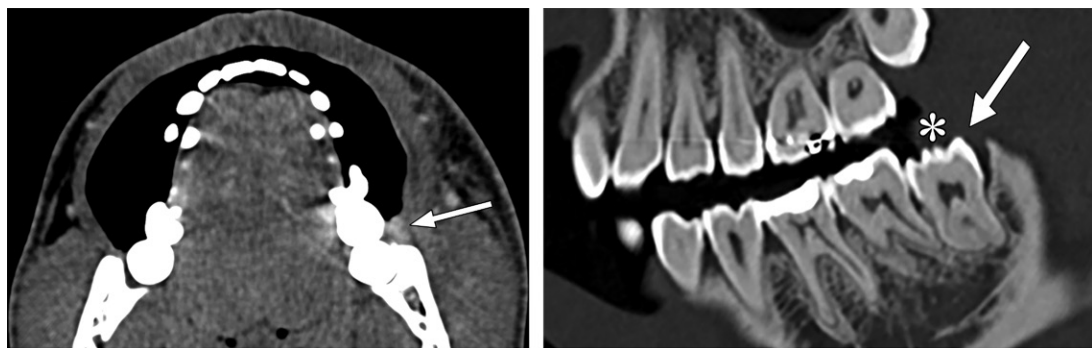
Pericoronitis. (a) Axial contrast-enhanced CT image (soft-tissue window) demonstrates enhancement of the pericoronal tissues (arrow). (b) Sagittal CT image (bone window) shows that the affected tooth is partially erupted (arrow) and partially covered by gingiva (*). (c) Axial contrast-enhanced T1-weighted MR image in a different patient also reveals pericoronal enhancement (arrow).
